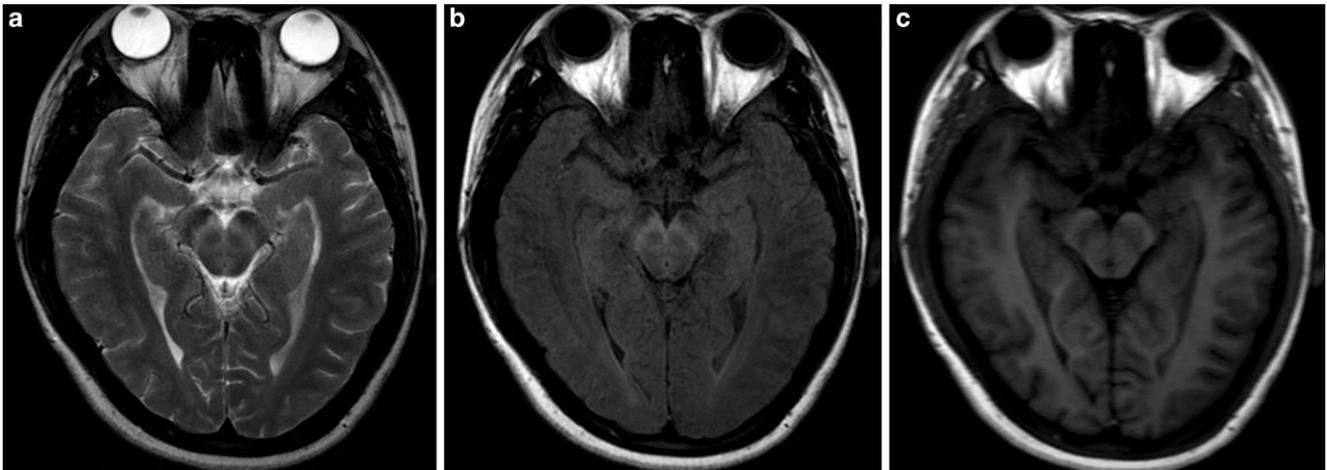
Axial MRI images at admission show lesions in the bilateral substantia nigra characterized by hyperintensity on a T2-weighted imaging and b fluid-attenuated inversion recovery sequences. c Hypointensity on T1-weighted imaging
